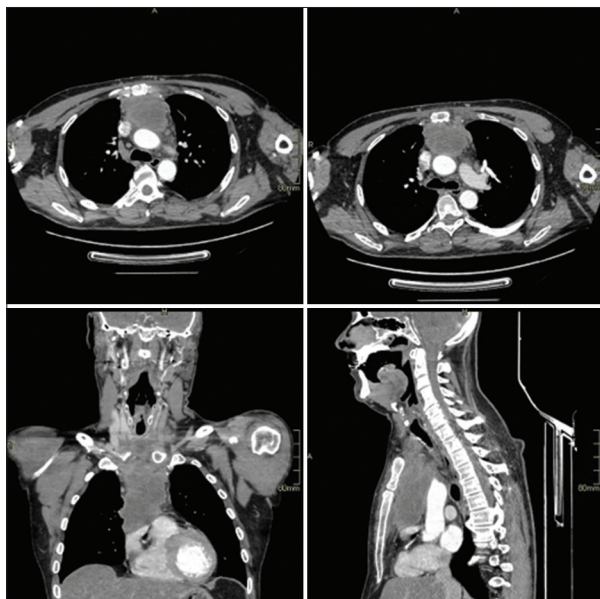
Cross-sectional, sagittal, and coronal computed tomography images showing possible thymic neoplasm and enlarged necrotic supraclavicular lymph nodes
